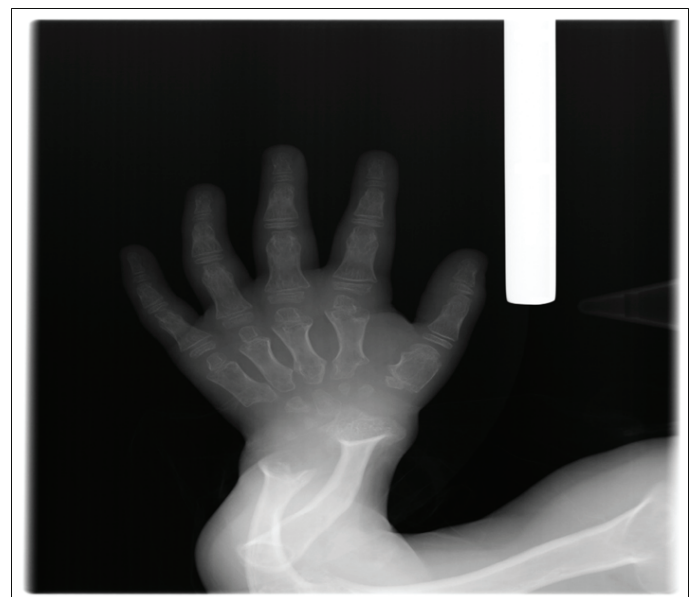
Hand wrist radiograph showing distal rounded tapering of the proximal and middle phalanges and irregularity of the metacarpal epiphyses
